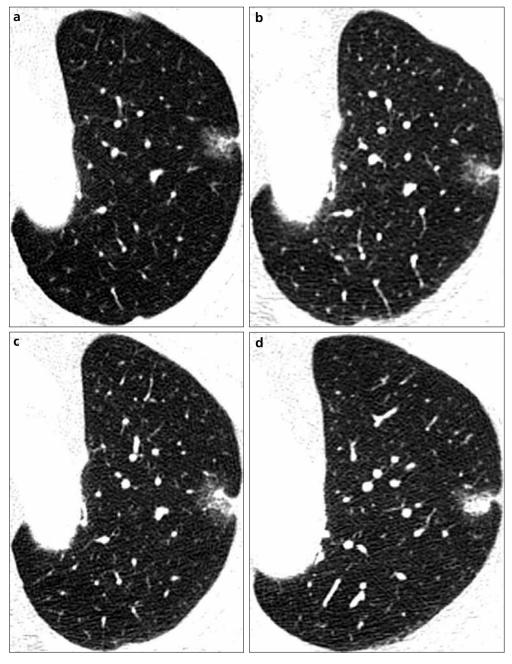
a-d. Progression of partsolid nodule at follow-up CT scans. Initial thin-section CT scan (a) shows a 10-mm part-solid nodule in the left upper lobe in a 74-year-old man. After 10 months, follow-up CT (b) shows no significant interval change of the nodule in the left upper lobe. Another follow-up CT (c) was obtained 34 months later. The part-solid nodule increased in size up to 22 mm. The internal solid portion (d) increased in size and extended into the lower portion of the nodule. The patient underwent lobectomy, and pathologic result was adenocarcinoma.
